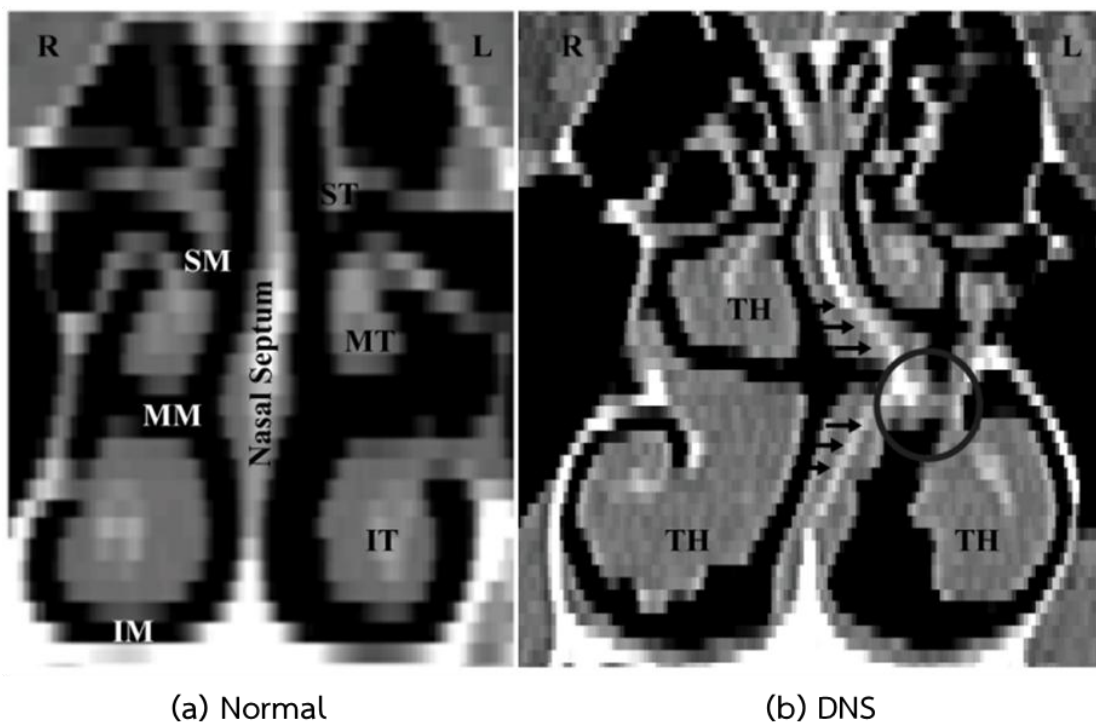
Coronal CT images compared between healthy nasal cavity (a) and leftward DNS (b), where IT is the inferior turbinate, MT the middle turbinate, ST the superior turbinate, IM the inferior meatus, MM the middle meatus, and SM the superior meatus. Compensatory turbinate hypertrophies (TH) are frequently observed in DNS noses.
